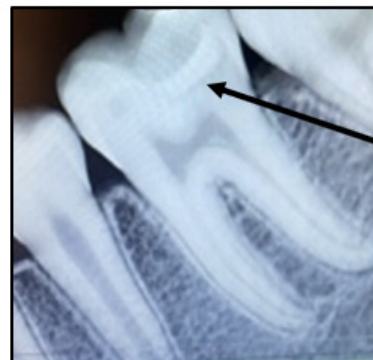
Radiographic appearance of biodentine as radiopacity on the floor.
